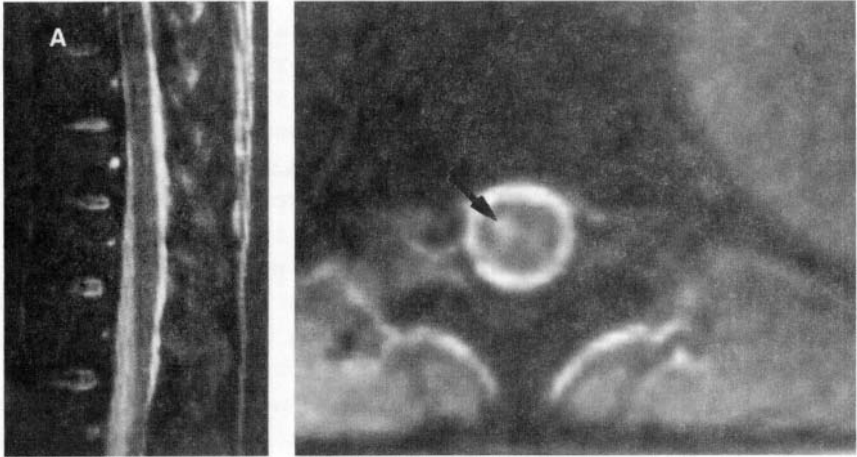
Conus myelitis. T2-weighted sagittal image (a) of the conus does not show any abnormality. T2-weighted axial image (b) at the level of dorsal 12 vertebra shows a hyperintense lesion (arrow) anteriorly and to the right. (Reprinted from Pradhan S, et al. *J Neurol Sci* 1998; 161: 156–162.)
